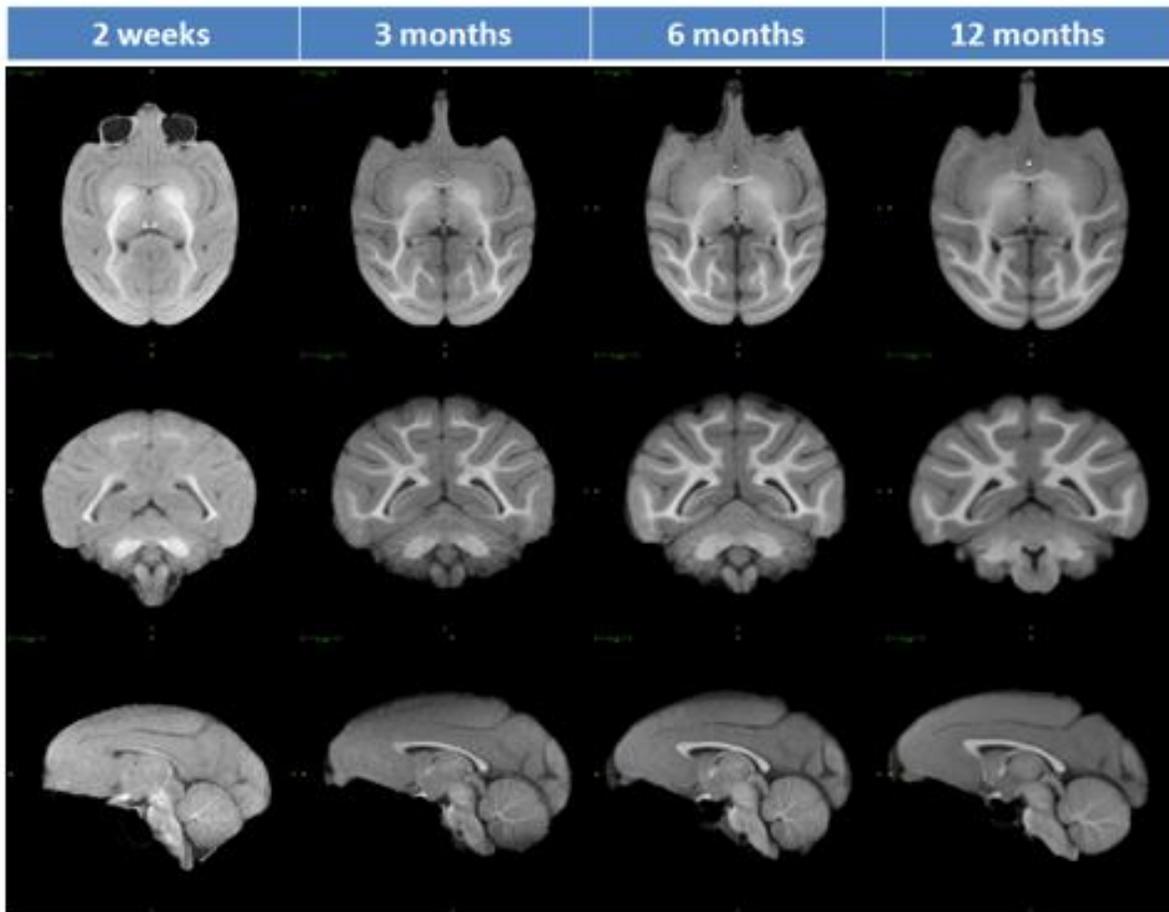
UNC-Emory infant rhesus structural MRI brain atlases. Reproduced from (Shi et al, 2017), with permission from the authors.
